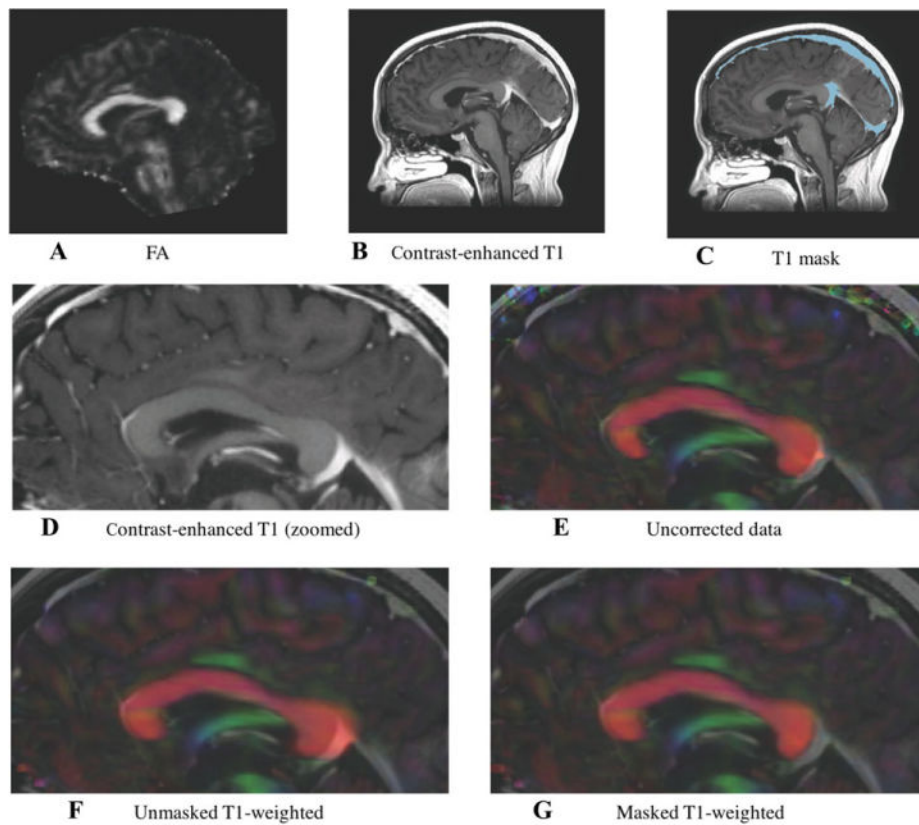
Effect of contrast enhancement on T1-based distortion correction method. Directionally encoded color images of the corpus callosum for one sample subject, showing the effect of contrast enhancement on the T1- based distortion correction method. (A) Fractional anisotropy map; (B-D) original contrast-enhanced T1-weighted image; (C) contrast-enhanced T1-weighted image with mask overlaid; (E) uncorrected DTI volume; (F) echo-planar imaging (EPI) distortion corrected data obtained with FAT1CC registration demonstrates “overstretching” of the corpus callosum; and (G) EPI distortion corrected data obtained with FAT1CC after masking brighter venous drainage resulting from the contrast enhancement in the T1-weighted volume.
